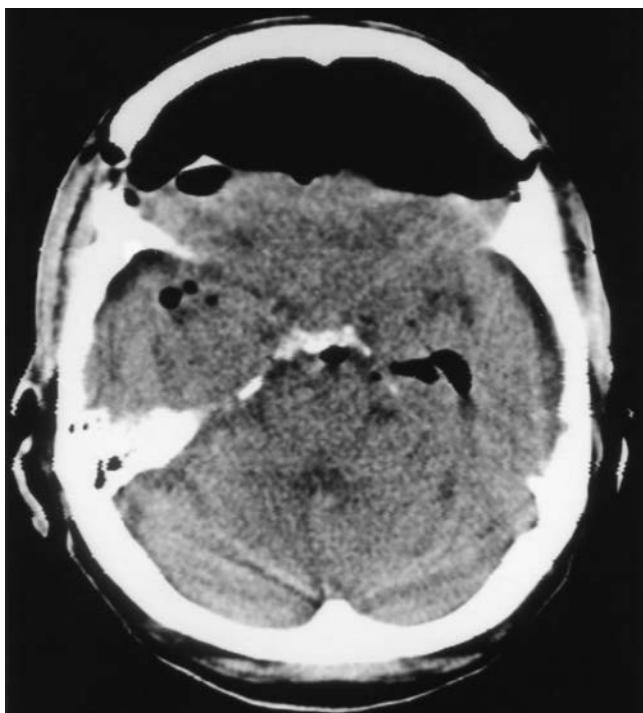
Postoperative computed tomographic scan demonstrating a large pneumocephalus after a subfrontal approach to a suprasellar glioma. Immediately postoperatively, the patient was confused and agitated, and he complained of a severe headache.
